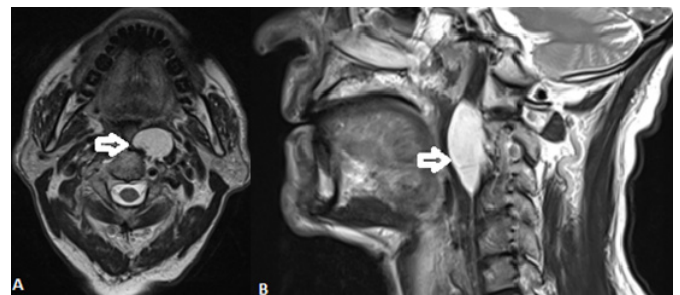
MRI images of the retropharyngeal space lipoma in the axial (A) and sagittal (B) planes, and its relationship with neighboring structures
